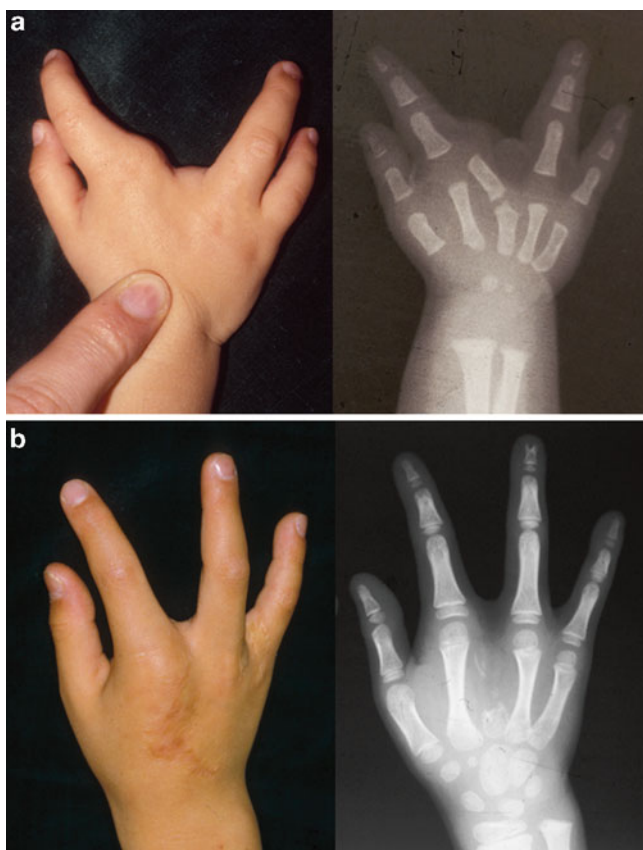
Excision of the cross bone. (a) Preoperative appearance and roentgenogram. At the age of 1 year 2 months, the cross bone and the third metacarpal were resected. Osteotomy of the second metacarpal base was performed and the cleft was close. (b) Postoperative appearance and roentgenogram: after surgery, good alignment has been achieved
